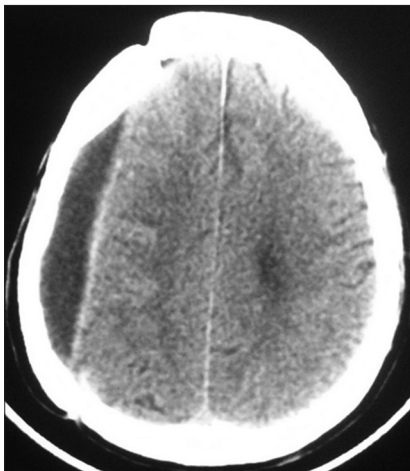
Non-contrast computed tomography of head showing recurrence of chronic subdural hematoma
